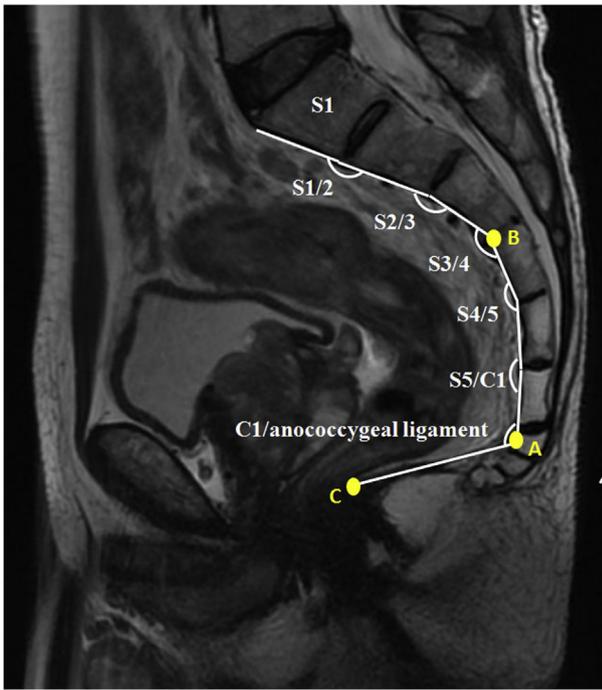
Variables measured on MRI. A 64 years old male patient’s sagittal T2WI MR image. The angle between the anterior surface of S1/S2, S2/S3, S3/S4, S4/S5, S5/c1 was 178.1°,162.3°,153.4°, 160.2°and 175.1°, respectively. The angle between the vertebrae surface above the departure point and the anococcygeal ligament was 111.7°. Based on the definition, point A was the departure point which was on the c1 level. Point B was on the S3/4 level. Point C was on the inserted point of anococcygeal ligament to the rectum wall.
